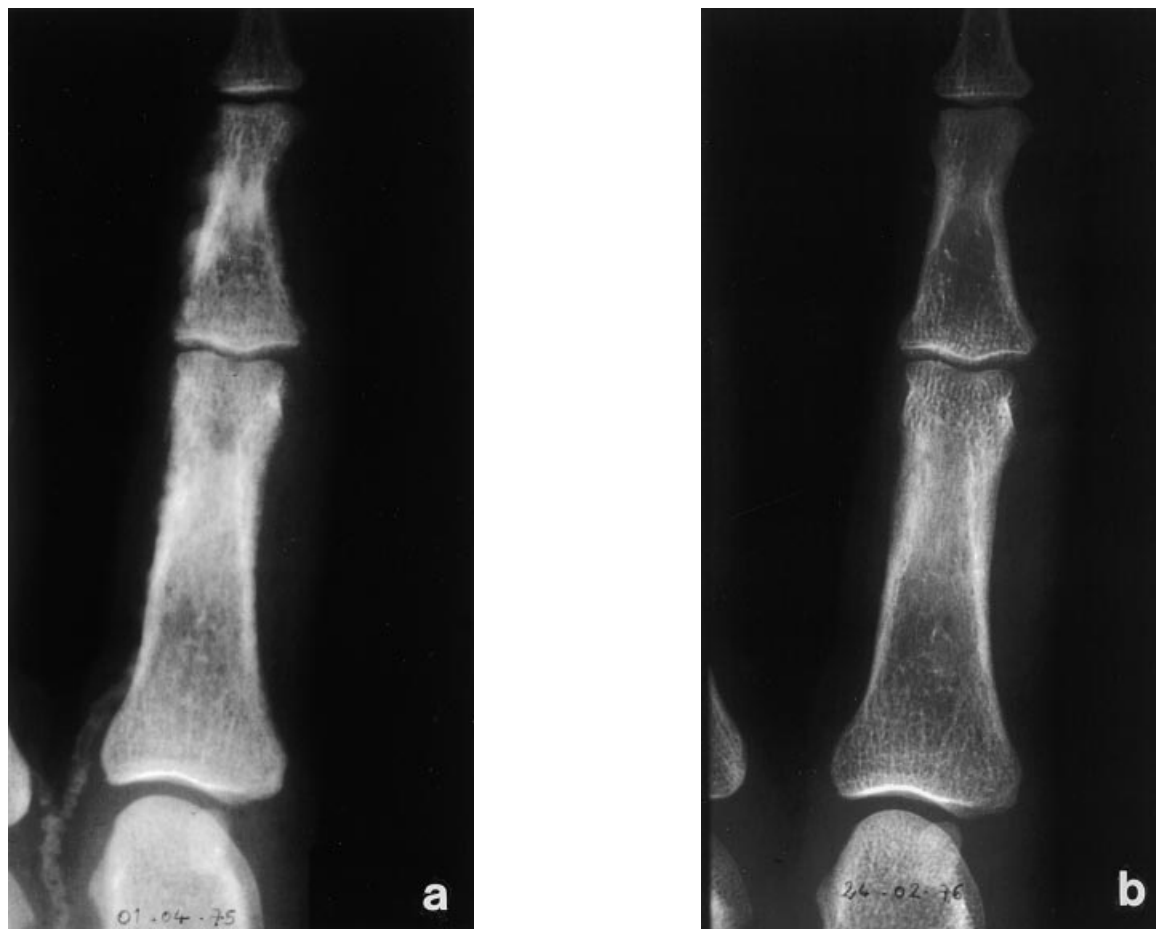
Radiograph of a single digit and calcified digital artery of a 36-year-old woman with ESRD from congenital uropathy (a) before subtotal PTX and (b) 11 months later when calcification had completely disappeared.
